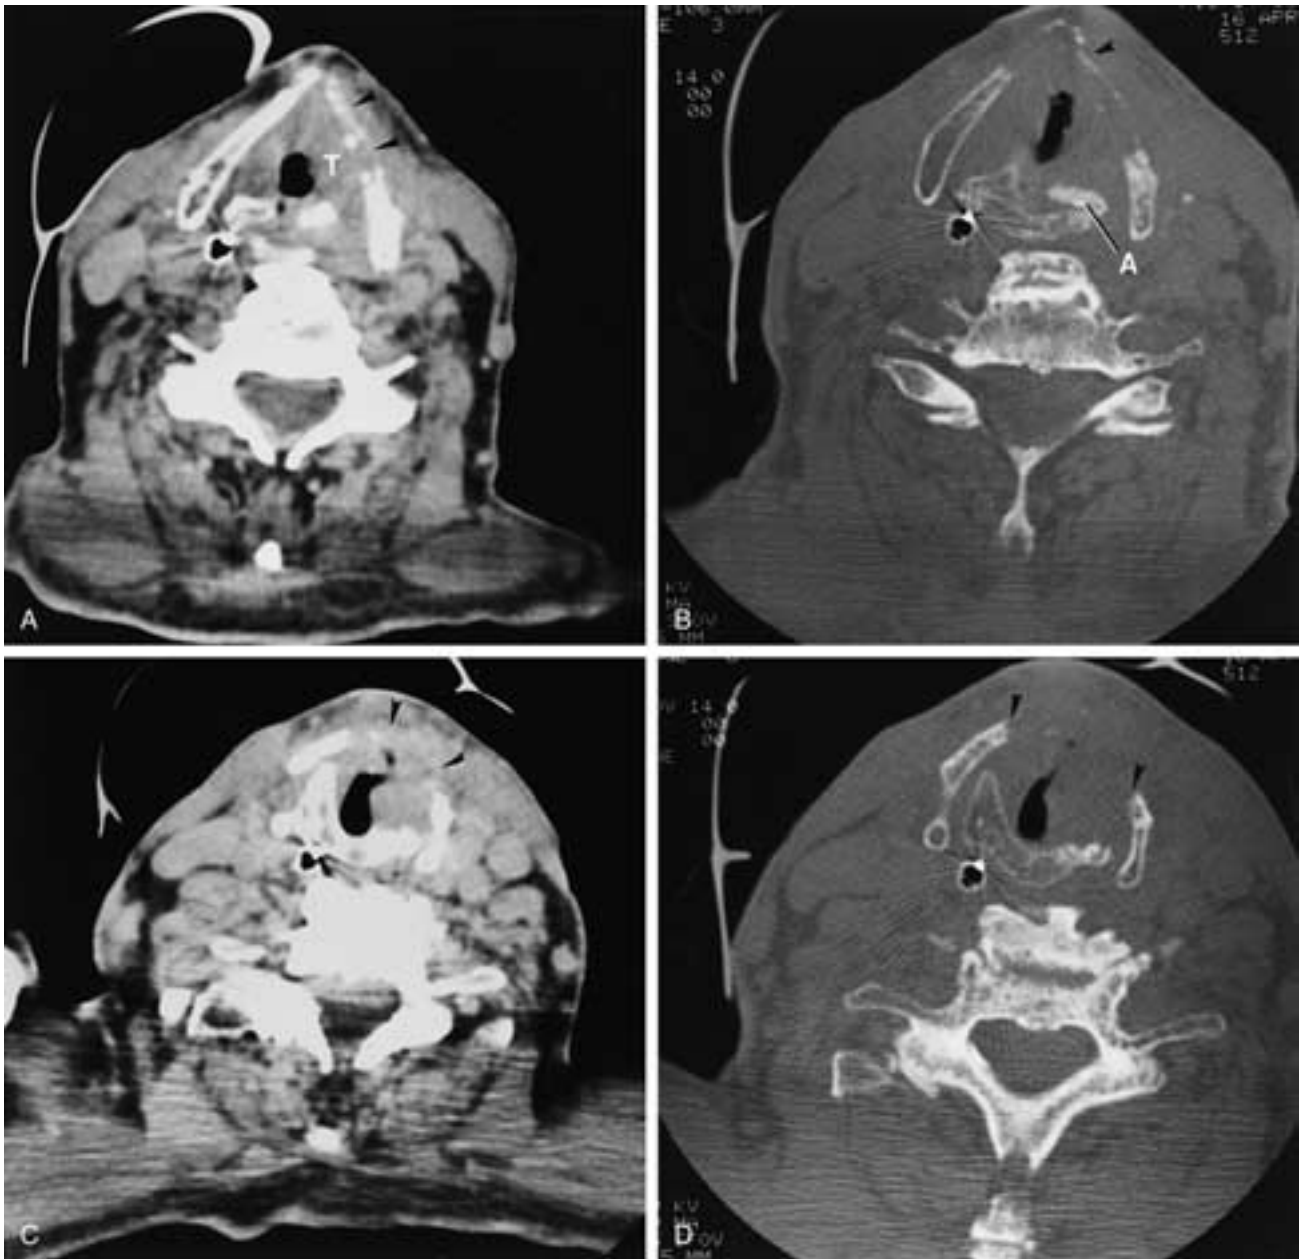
Axial CT scans of a transglottic tumor with cartilage destruction. A, The level close to the ventricle shows the tumor (*T*). There is definite demineralization of the thyroid ala (*arrowheads*) but no significant thickening of the strap muscles on the outer surface of the thyroid. B, Bone algorithm shows the demineralization of the cartilage, which is strongly indicative of tumor invasion. There has been slight buckling (*arrowhead*) of the thyroid ala because of the weakening of the cartilage. The arytenoid (*A*) is sclerotic. C, Scan through the cricoid shows tumor within the ring of the cricoid and, at this level, tumor extending outside of the larynx (*arrowheads*). D, Bone algorithm showing destruction of the thyroid cartilage (*arrowheads*).
